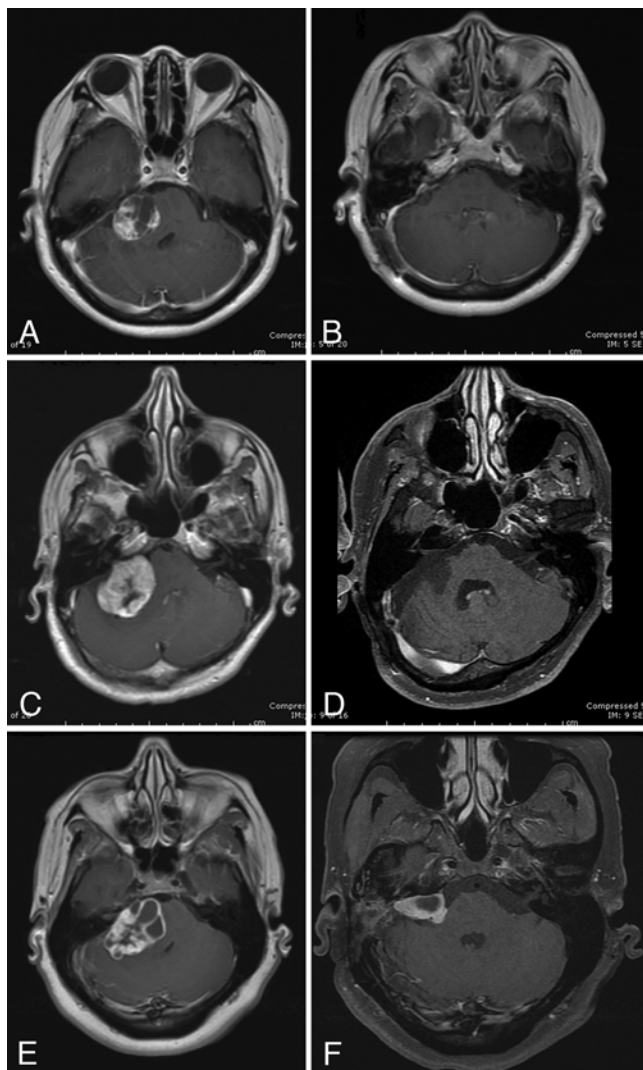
Axial T1-weighted contrast-enhancing MR images demonstrating single cystic or multicystic VSs. Images obtained in a 49-year-old woman, showing a right-sided multicystic VS preoperatively (A) and successful GTR via a retrosigmoid approach at the 1-year follow-up (B). This patient had HB Grade I facial nerve function after treatment. Images obtained in a 50-year-old man, demonstrating a right-sided central single CVS preoperatively (C) and successful GTR via a retrosigmoid approach at the 5-year follow-up (D). This patient had HB Grade IV facial nerve function after resection. Images obtained in a 45-year-old woman, showing a right-sided multicystic VS preoperatively (E) and successful STR via a translabyrinthine approach at the 4-year follow-up (F). This patient had HB Grade I facial nerve function after resection, although a cystic component not present on the immediate postoperative MR image later recurred (not shown).
